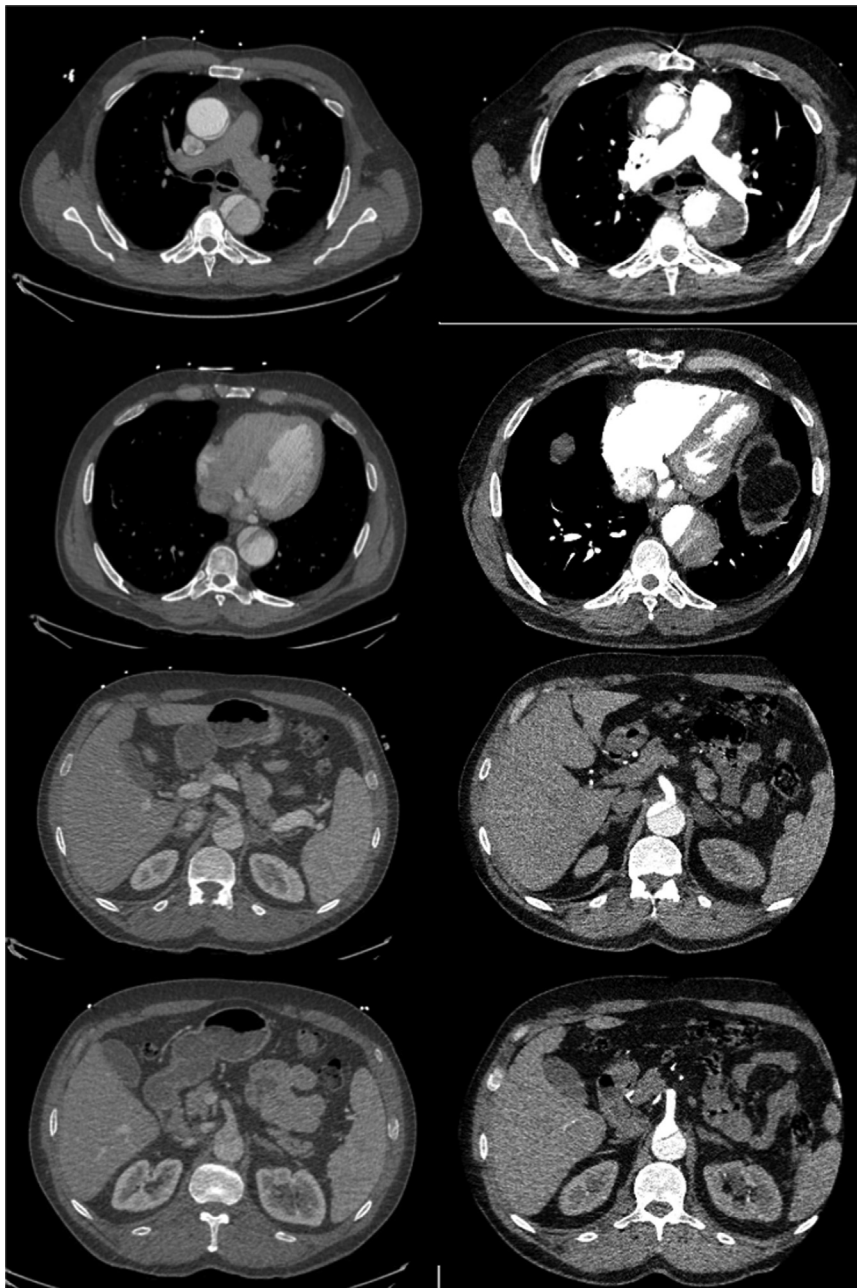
Computed tomography imaging showing preoperative and postoperative HAR with TEVAR.
